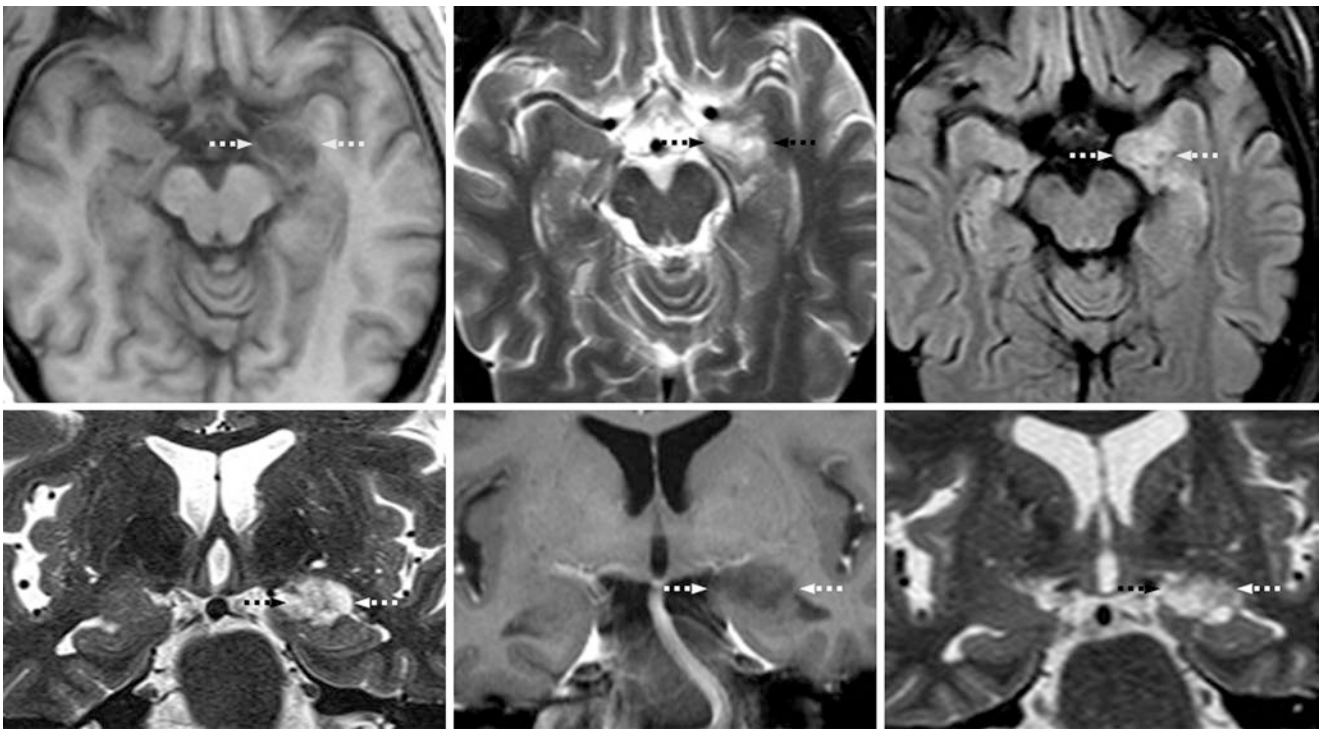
Comparison case of low-grade astrocytoma. A 51 year old with seizures underwent a 1.5 T MRI with axial T1WI (top left), T2WI (top middle), FLAIR (top right), coronal T2WI (bottom left), and postcontrast coronal T1WI (bottom middle). All showed a medial left temporal lobe mass (dotted arrows) that was hyperintense on T2WI but not cystic on FLAIR. This was later proven to be a low-grade astrocytoma. It was unchanged 3 years later on coronal T2WI (bottom right)
